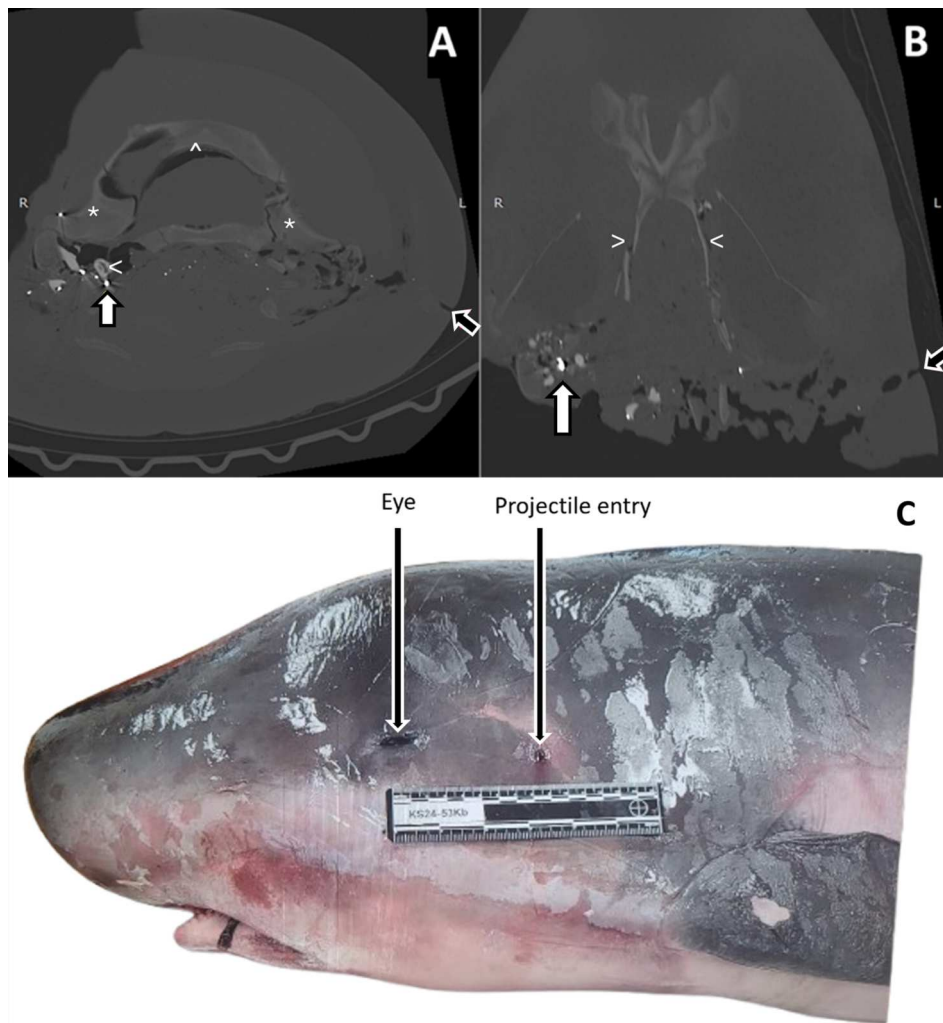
Multiplanar reconstruction CT of a pygmy sperm whale (*Kogia breviceps*) in a high-frequency algorithm with an extended CT scale (window width: 9,000 HU; window level: 2,000 HU). (A) Transverse view of the caudal aspect of the skull with the entry wound (black arrow) and fragments of the metal bullet (white arrow) lodged within the fractured right petrous temporal bone (>). The temporal bones (*) and occipital bone (^) are indicated. (B) Dorsal view with the same entry wound (black arrow) and metal ballistic fragments at the terminal trajectory within the right petrous temporal bone (white arrow). Pterygoid bones are indicated (<). (C) External view of pygmy sperm whale with a lateral projectile entry wound caudal to the left eye.
